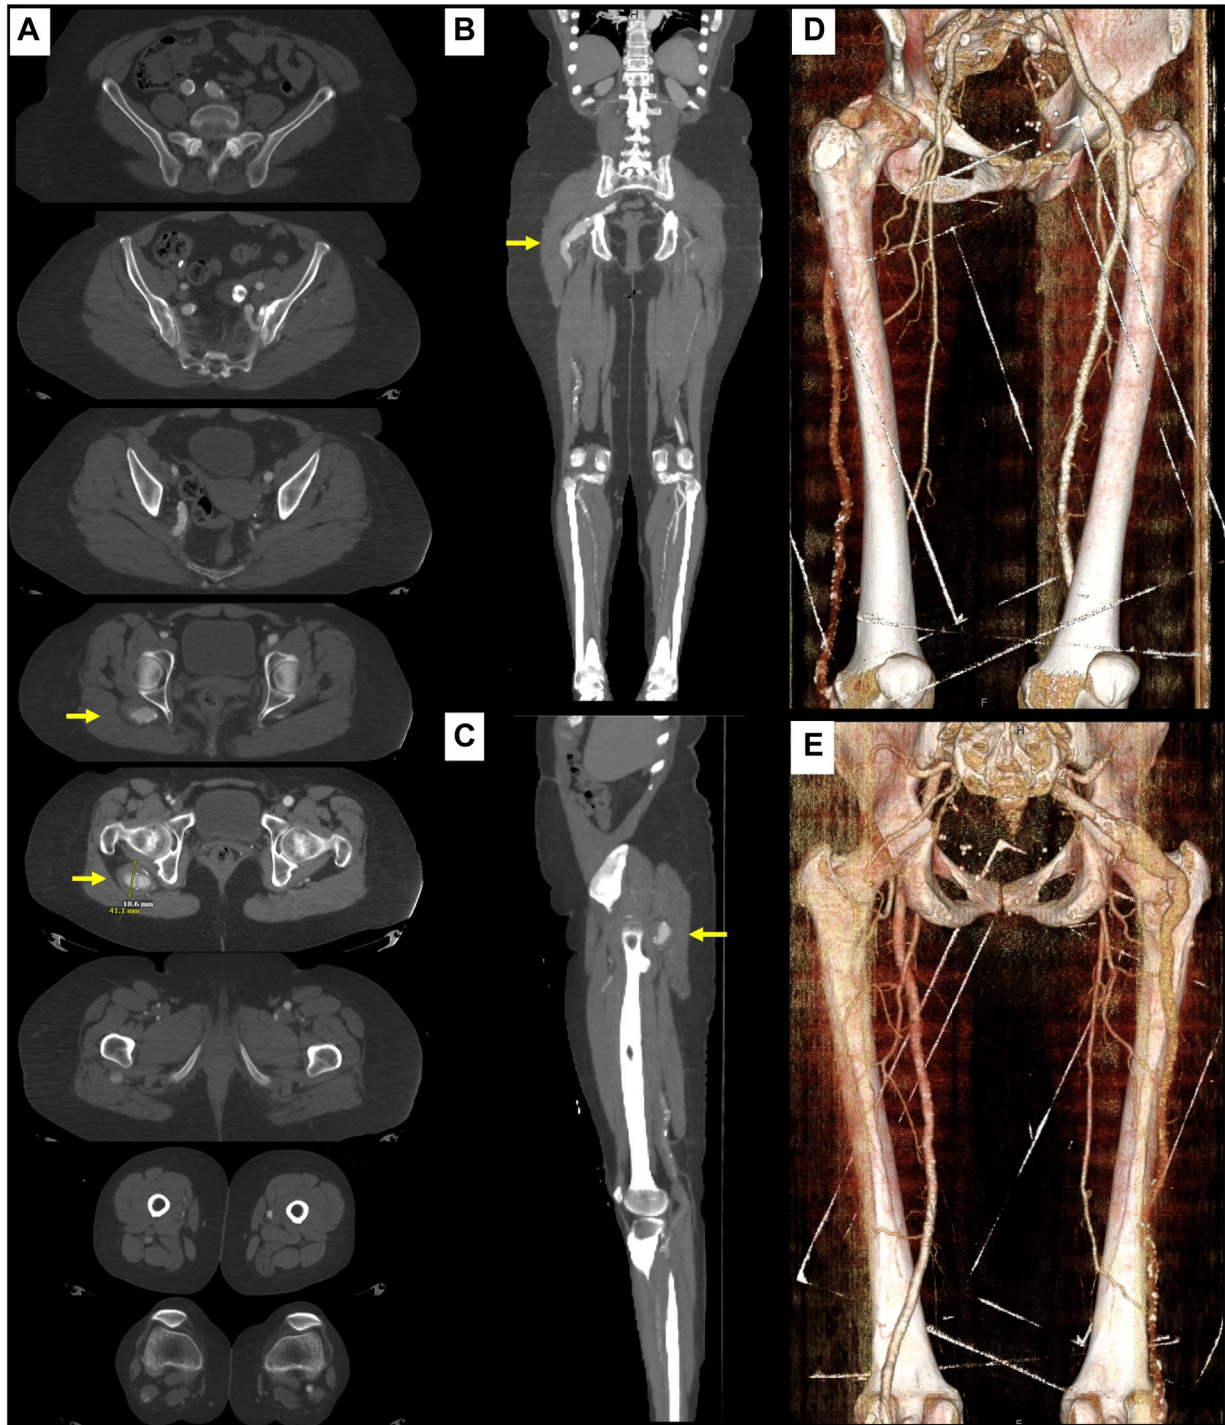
Computed tomography angiogram (CTA) of the aorta with runoff showing a right persistent sciatic artery (PSA) fusiform aneurysm with degeneration (yellow arrow) and mural thrombus. The maximal diameter of the right PSA aneurysm measured 4.1 cm with a patent lumen measuring 1.9 cm. The right external iliac, common femoral, and profunda arteries were patent. The right common femoral artery (9.1 mm) was smaller in caliber than the left common femoral artery (11.4 mm). The right superficial femoral artery was hypoplastic but was patent to the level of the lower thigh. The right sciatic artery was in continuity with the popliteal artery. A, Axial views of multiple cross-sectional levels. B, Coronal view. C, Sagittal view. D, Three-dimensional reconstruction of anterior view. E, Three-dimensional reconstruction of posterior view.
